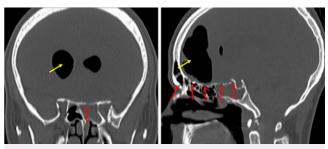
Case 2. Left: Preoperative coronal CT with pneumocephalus (*yellow arrow*) and multiple fractures (*red arrow*). Right: Preoperative sagittal CT with pneumocephalus (*yellow arrow*) as well as orbital, ethmoid, and sphenoid fractures (*red arrows*).
